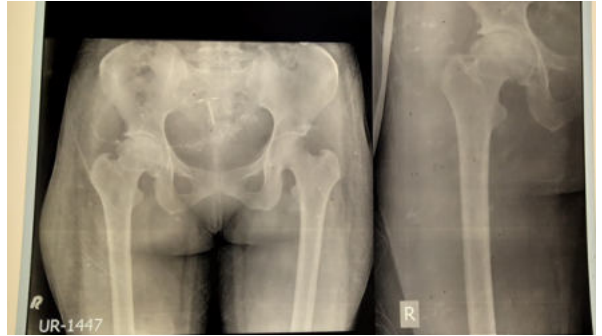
Preoperative Radiograph of 28 years old female suffering from Grade 3 AVN
